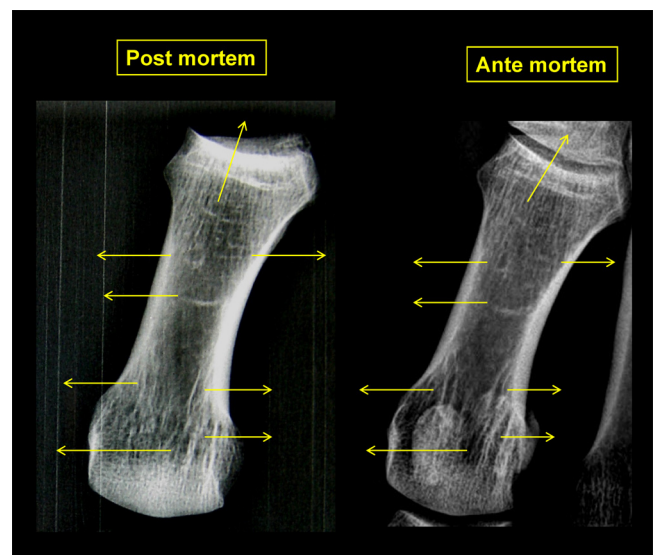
Trabecular comparison of the first metatarsal. 8 obvious points of comparison are underlined on the figure, but there were more than 30 useful points of comparison within this first metatarsal. There are some differences between some specific points, but there are due to the slight difference of the orientation of the radiological beam, and slight difference in average radiological density between ante mortem and post mortem X-rays.
